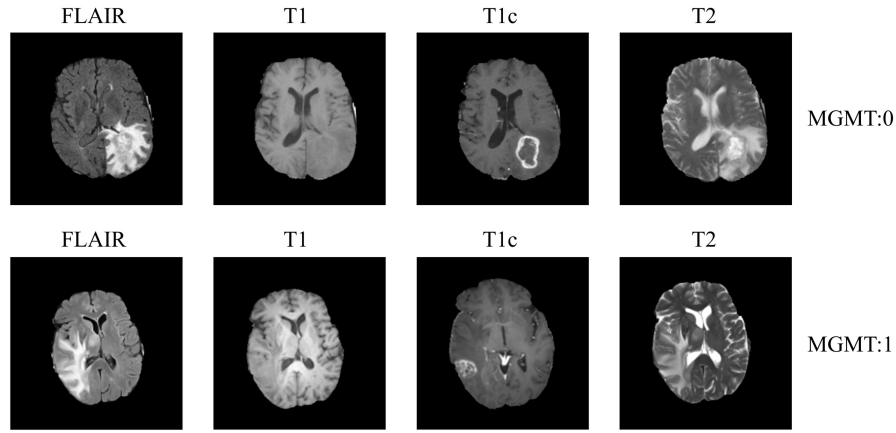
Four MRI modalities of patients with different MGMT promoter methylation status.
